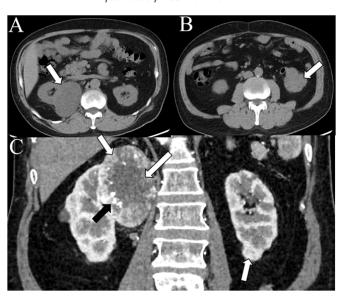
Masses were found in both kidneys of a 62 year old man during his routine health checkup by ultrasound. Contrast-enhanced computed tomography (CT) images show enhancing masses in the upper pole of the right kidney with the biggest being 77×52mm [white arrow in A (plain scan) and C (arterial phase)] and lower pole of the $left kidney with the biggest being of 51 \times 36 mm [white arrow in B (plain scan) and C (arterial phase)]. Obvious enhancement of vascular (black arrow in C) and necrosis were the properties of the properties o$ found in the right renal mass (long white arrow in C). Tumors of both kidneys were highly suspected based on the contrast CT findings.
